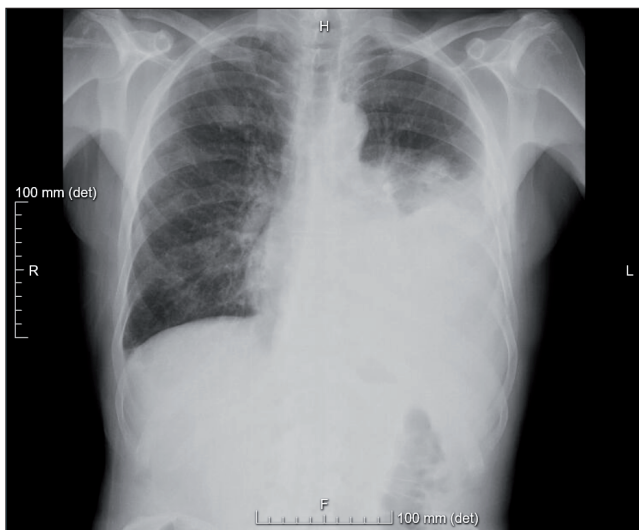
Chest X-ray: hypotransparency in the lower half of the left hemithorax, suggestive of pleural effusion and passive pulmonary atelectasis, and small bilateral cotton-wool opacities.
